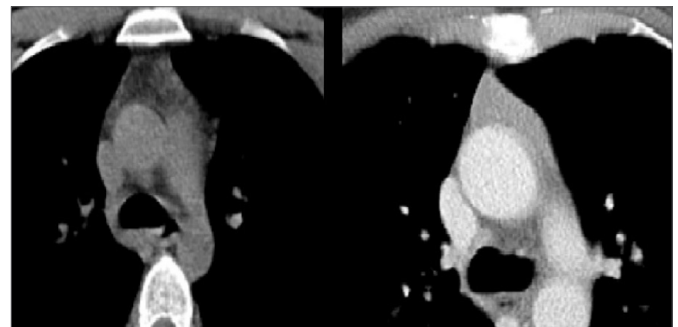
CT image example of quadrilateral (a) and triangular (b) shapes of the thymus.
